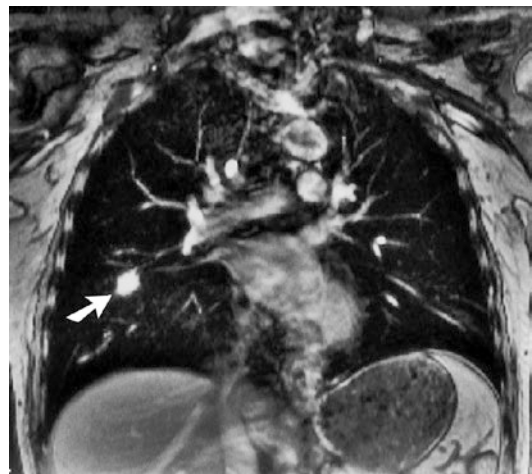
A 45-year-old male patient with invasive aspergillosis. Postcontrast T1-weighted FLASH (TR >200 ms, TE = 4 ms, FA = 80°) shows a strongly enhancing, ill-defined round infiltration (arrow) (With permission of Springer: Kauczor and Kreitner 1999)
